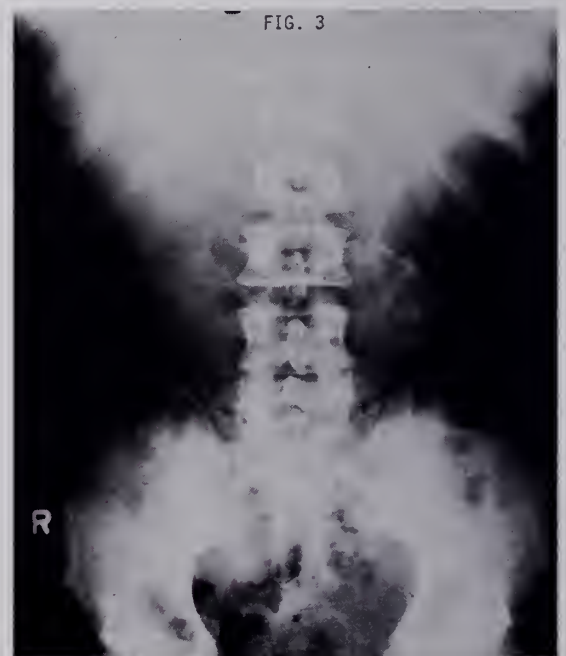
Abdominal radiograph after removal of catheter.
